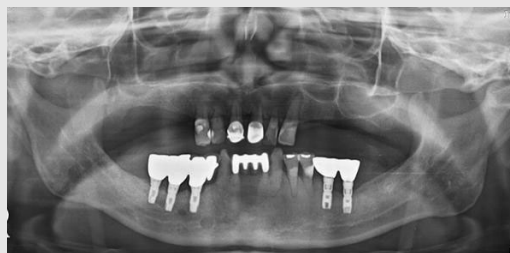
Radiographic evaluation after 2 years implant loading. The implant do not show any crestal bone loss.
